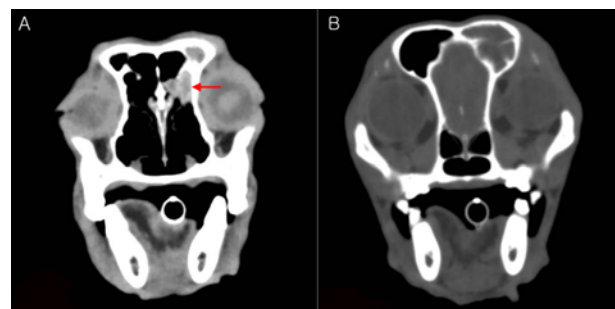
Plain computed tomography (CT) images on transverse view. A: The mass (arrow) is identified at the caudal portion of left nasal cavity. B: Soft tissue materials mixed with bone materials are filled in left frontal sinus.
